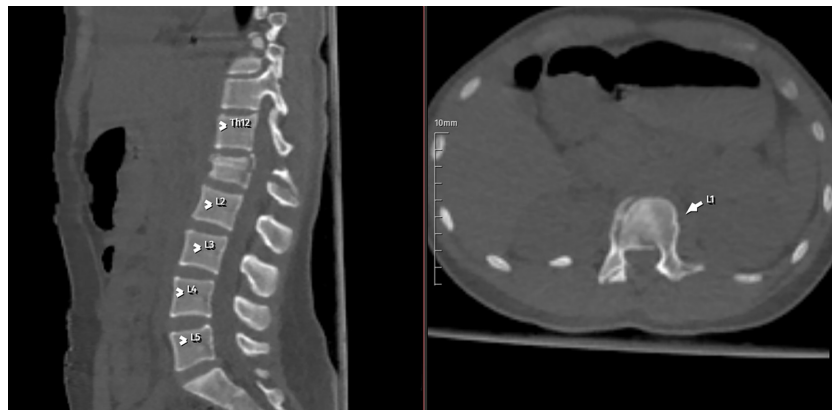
CT imaging of patient with L1 spine fracture after e-scooter injury
